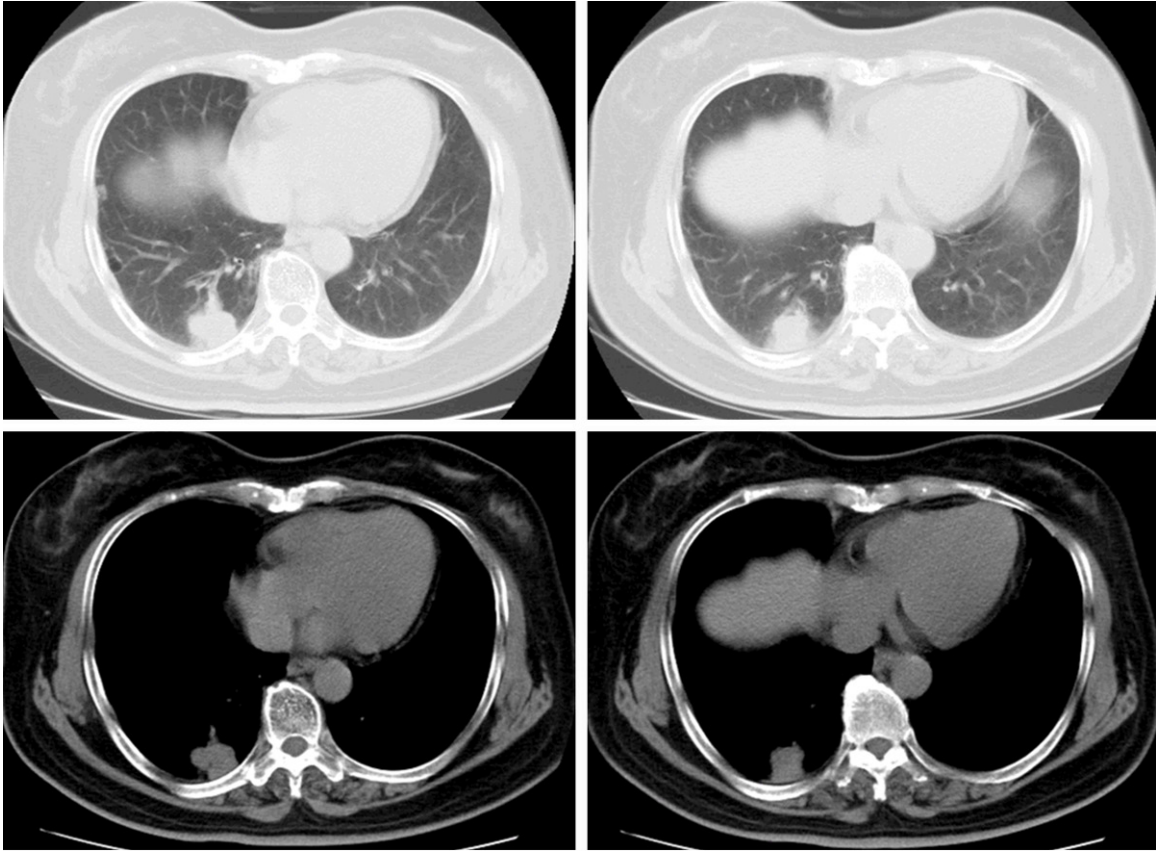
Computed tomography (CT) image revealing a solitary pulmonary nodule in the right lower lobe of the lung.
